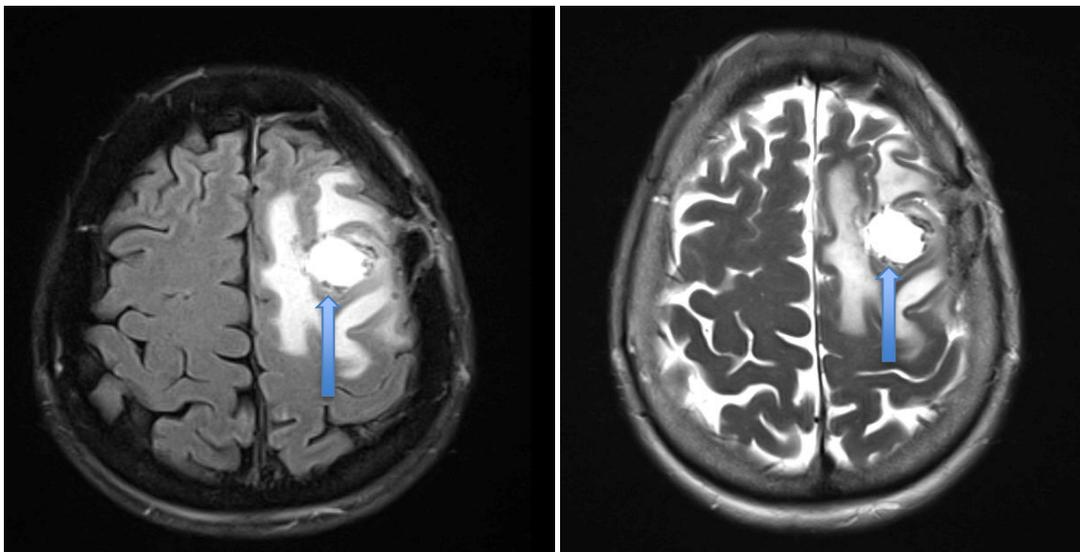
Post op brain MRI, GTR resection (blue arrow)
